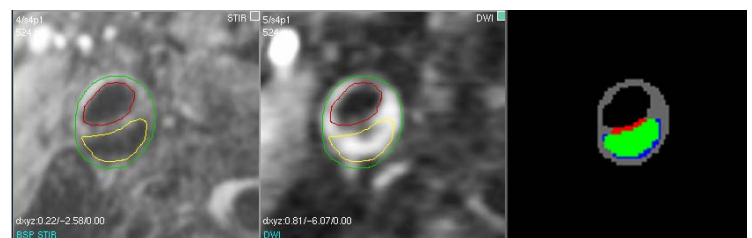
STIR and DWI images of a lipid lesion. Image at the right shows in green the overlap between the automatic and manual segmentation (red = false positive region, blue = false negative region).
